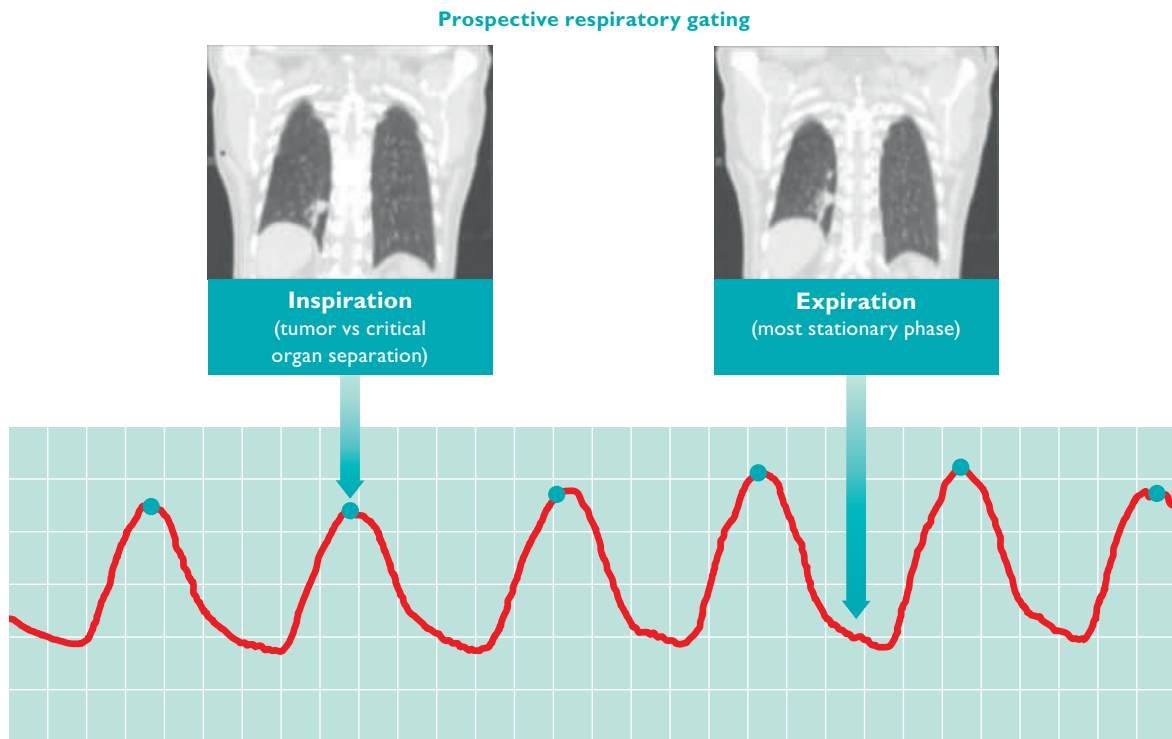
Example of 2 prospective CT scans. Image on the left represents end inspiration phase of respiratory cycle. This image is synchronized with respiratory waveform (above). Arrow points to the specific phase. Image on the right represents end expiration phase of respiratory cycle. This image is synchronized with respiratory waveform (above). Arrow points to the specific phase.
